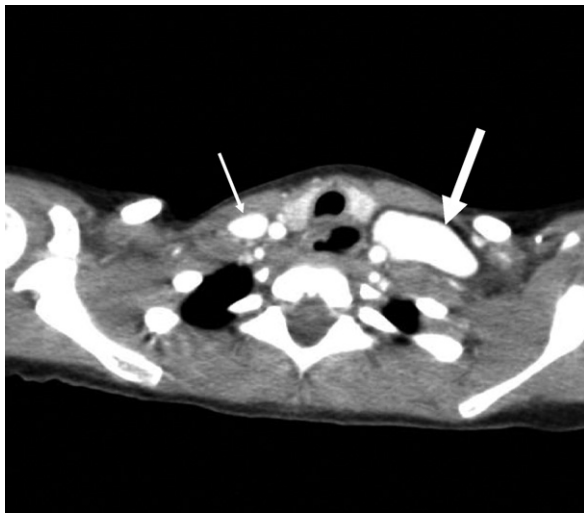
A computed tomography scan of the left jugular vein at the apex of the lung during a Valsalva maneuver reveals the dilated left jugular vein (*thick arrow*) and the normal right jugular vein (*narrow arrow*).
